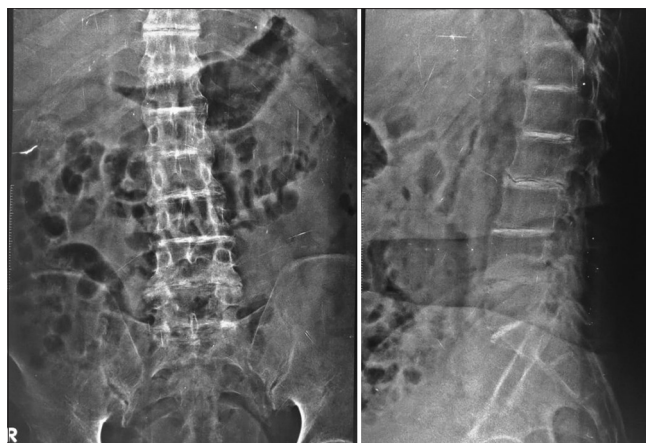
Radiograph of lumbosacral spine in anteroposterior and lateral view showing ossified intervertebral disc with slight erosion of adjacent vertebral margins
